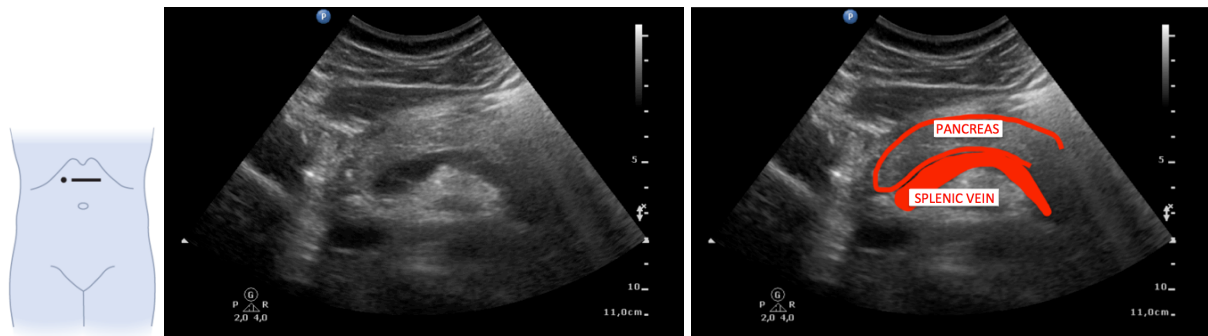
Ultrasonographic examination of the epigastric region.
